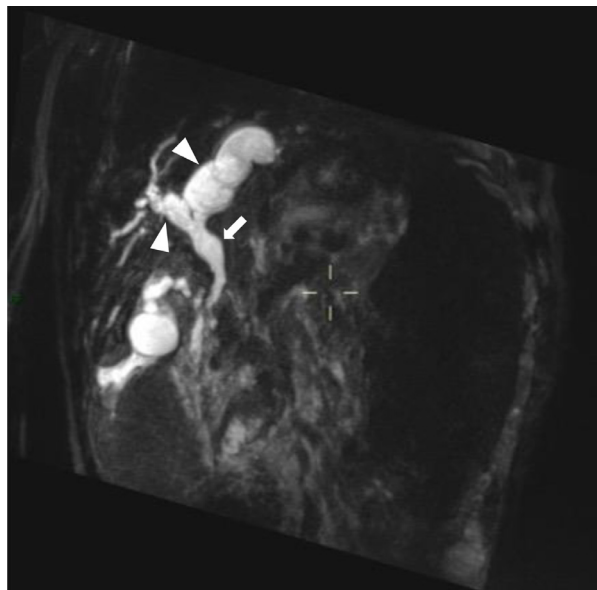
Coronal MIP thick T2-weighted MR cholangiogram depicting dilatation of left and right hepatic duct (arrowheads) and common bile duct (arrow) with no evidence of lithiasis.
